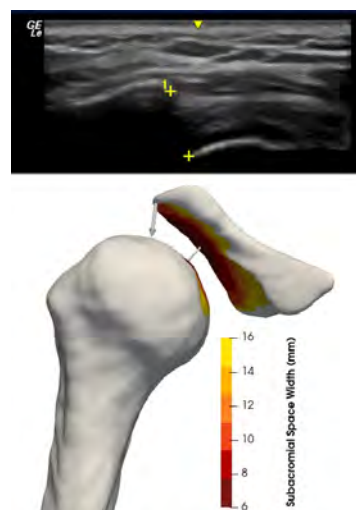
SAS measured from US (top) and MRI (bottom)
